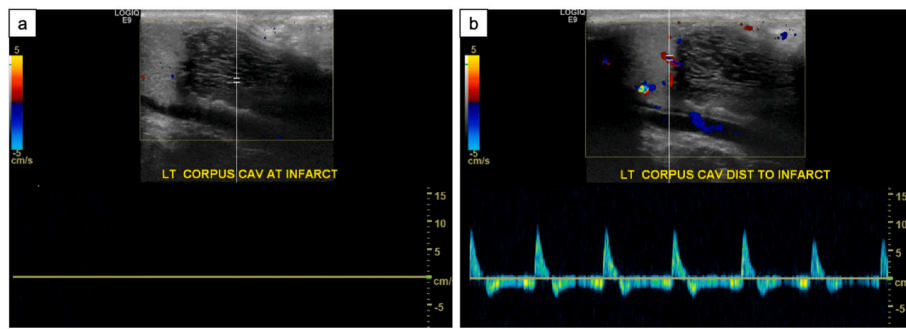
(a) Hypoechoic area corresponding to the abnormality seen in the left corpus cavernosum with no internal vascularity and absent flow on the spectral Doppler images. (b) Arterial flow is demonstrated in the distal portion of the left corpus cavernosum.
